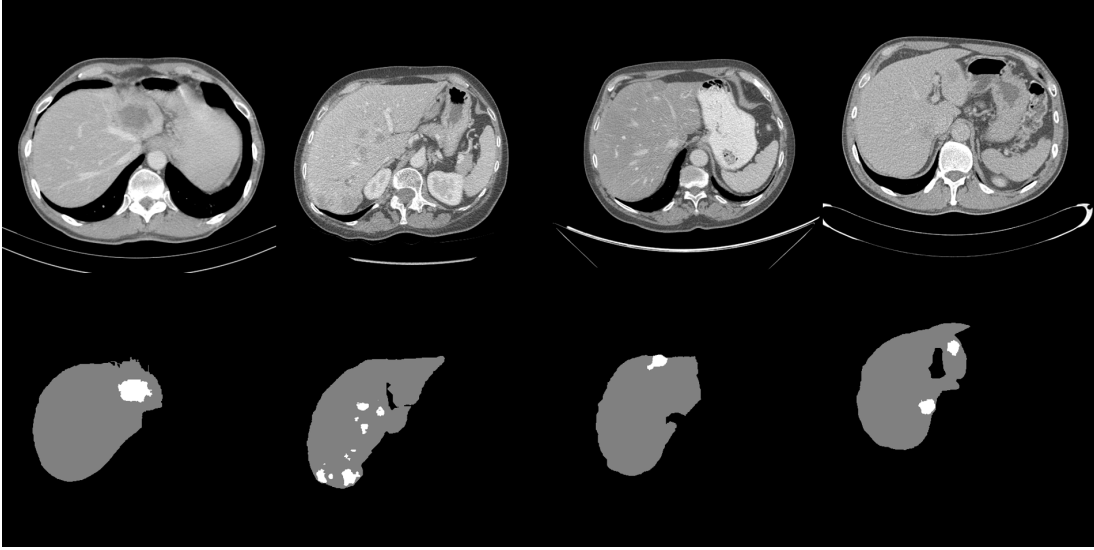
Example data from the LiTS dataset. Top row shows the CT images, bottom row the corresponding segmentation of liver (grey), and lesions (white). $C = 0$ HU, $W = 500$ HU.
